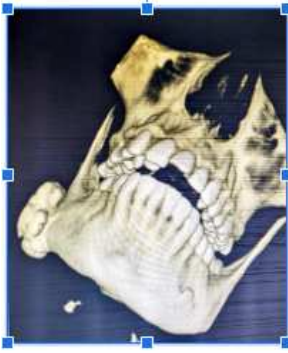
Cone Beam Computed Tomography Showing Osteoma Of Right Hemimandible
